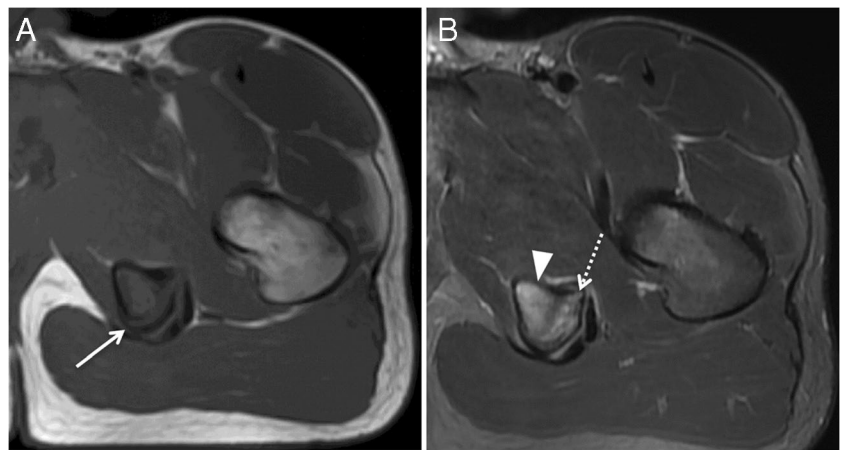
14-year-old male, soccer athlete with ischial tuberosity apophysitis, presenting with posterior hip pain for 1 month. Axial T1-weighted (A) and axial T2-weighted fat-suppressed (B) MRI of the left thigh show hypertrophy of the apophysis (arrow) of the ischial tuberosity, with bone marrow edema of the apophysis (dotted arrow) and subapophyseal bone (arrowhead). These findings are consistent with apophysitis
